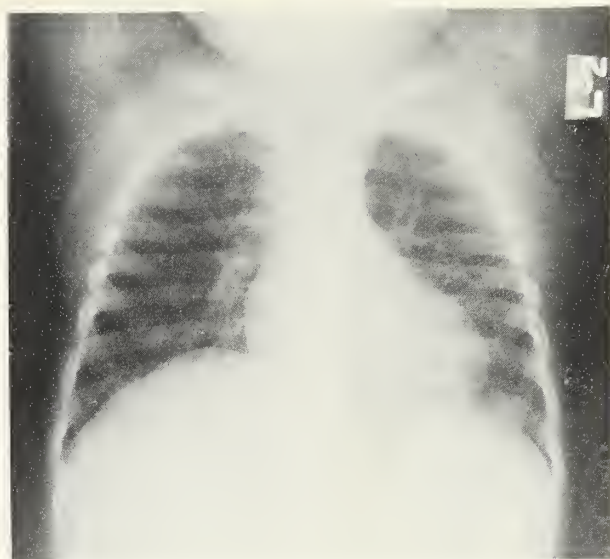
Postoperative chest X-ray (case #1) shows reduction in the heart size and clearing of the pulmonary edema.
